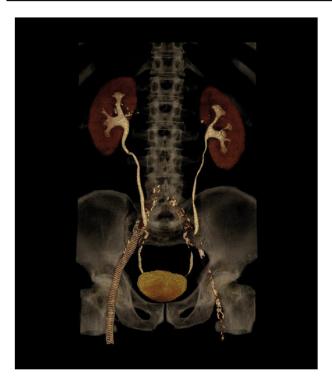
Computed tomography scan showing the proximal extremity of the endovascular stent laying at the crossing with the right ureter.
